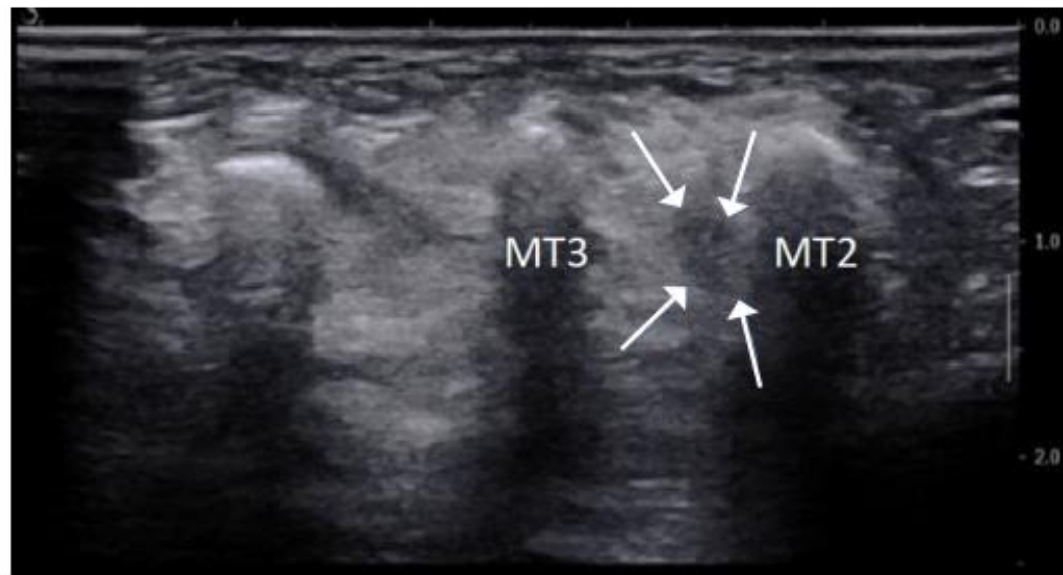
A 63-year-old patient with electrifying pain while walking between metatarsal (MT) 2 and 3. On ultrasonography, a hypoechoic Morton's neuroma (arrows) between the heads of MT 2 and 3 is visible.
